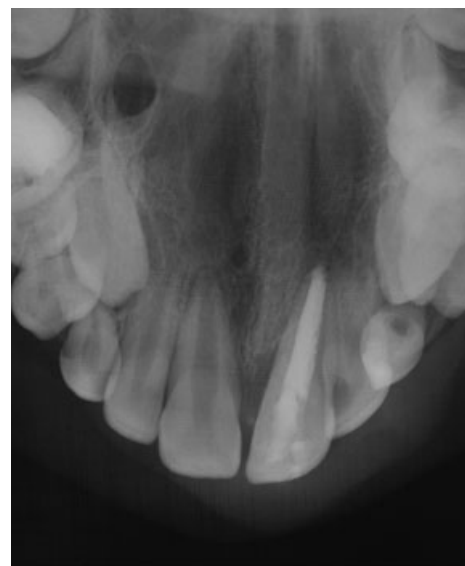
Radiographic view of the tooth 2 weeks after operation.
